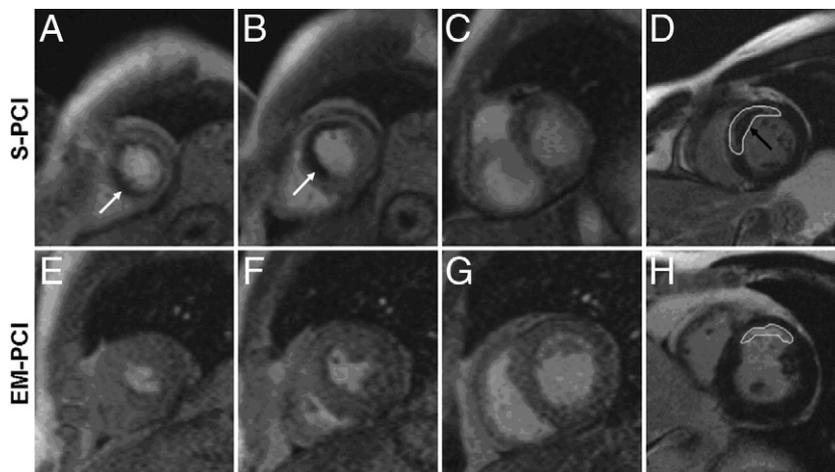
Cardiovascular MRI
